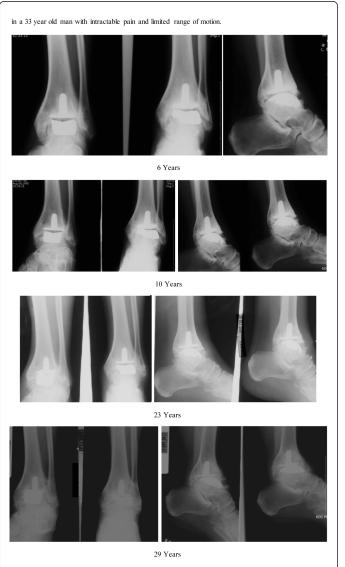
Sequential AP and lateral X-rays of the left ankle in the patient from Figure 1 with a cementless B-P shallow-sulcus ankle after 6, 10, 23 and 29 years, respectively. Note the progression of anterior and posterior osteophytes with time, and the nearly-complete wear- through of the meniscal bearing after 29 years.
